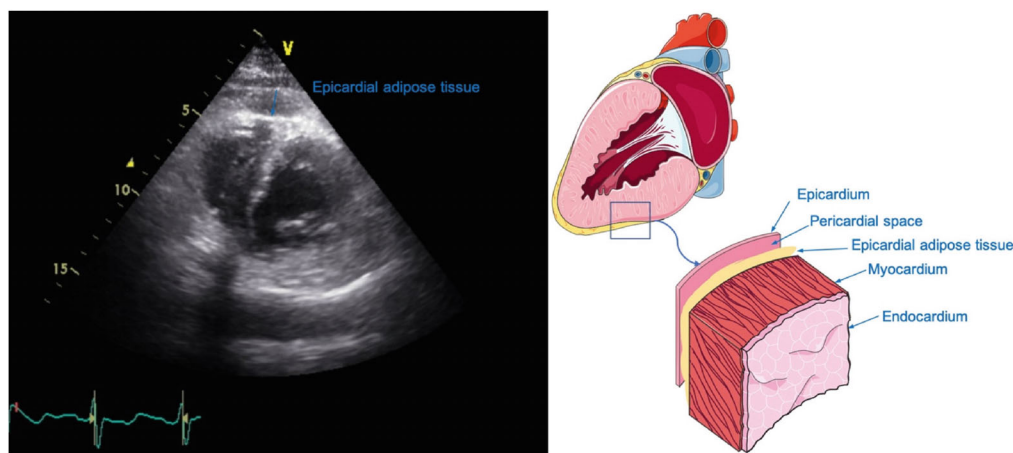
Anatomy of epicardial adipose tissue and example with landmark taken from the parasternal short-axis view.
